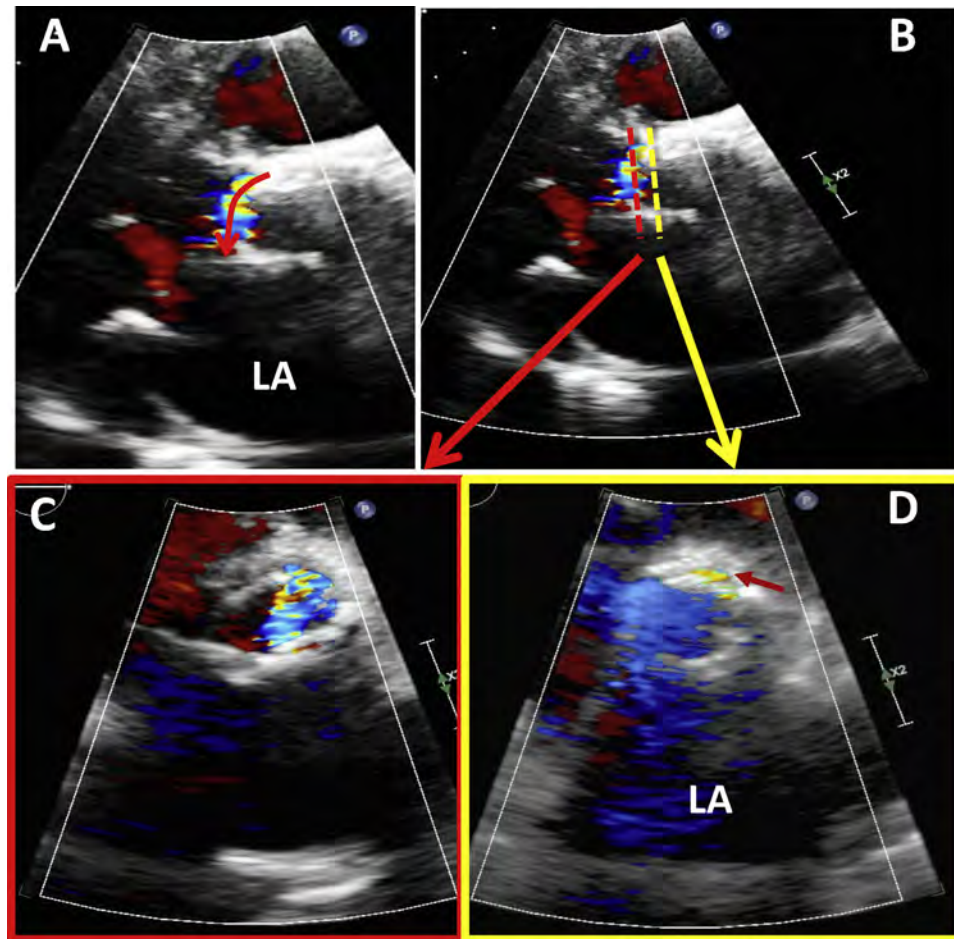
Effect of AR eccentricity on color Doppler jet recording in assessing PVR severity after TAVR. Scanning of the whole stented valve in short axis is needed to identify the vena contracta of the jet(s). Proper plane selection of the short axis is critical. In the case of an eccentric jet in the LVOT (A; *curved arrow*), the plane below the valve ring (B; *dashed red*) shows a large color jet as it spreads in the LVOT (C), overestimating AR severity. By selecting the proper short axis at the aortic annulus (D), the regurgitant orifice is best depicted (*small red arrow*), more consistent with mild PVR. Similarly, a high short-axis view at the aortic root level (not shown) could be misinterpreted due to normal diastolic flow in the sinuses of Valsalva or coronary arteries; flows in these locations, however, are of lower velocity and are not aliased.
